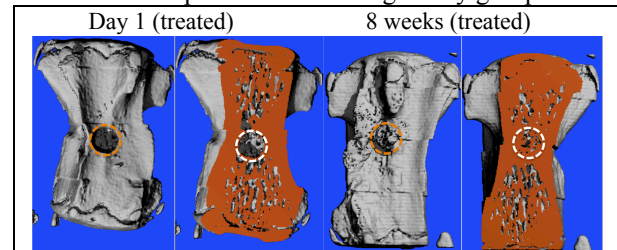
μ CT analysis *in vivo*. 8 weeks post operation the defect was healed with ASC-BMP6.
